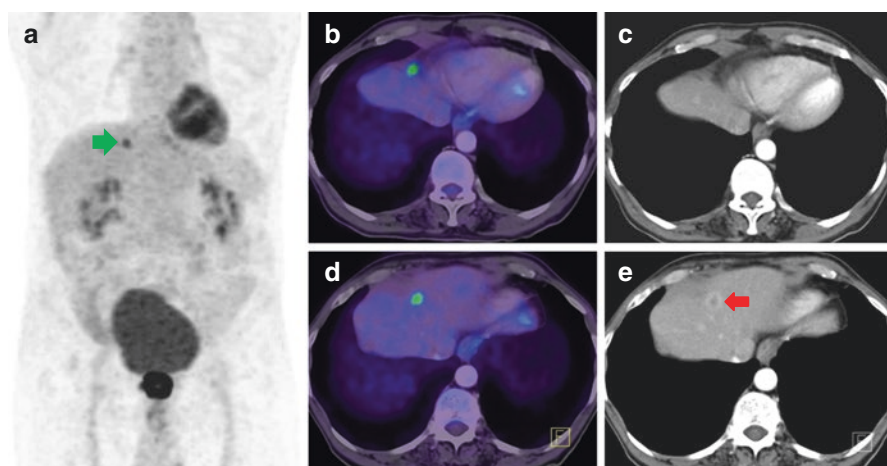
Case of carcinoma of the rectum ^{18}F -FDG PET/CT for initial staging reveals focal FDG uptake in the liver (b) with no corresponding lesion seen in CT part (c). Review of MIP shows the lesion to be significant (green arrow) (a). Movement misregistration is manually corrected, and corresponding CT image shows a peripherally contrast-enhancing lesion in segment VIII of the liver (red arrow) (e)
